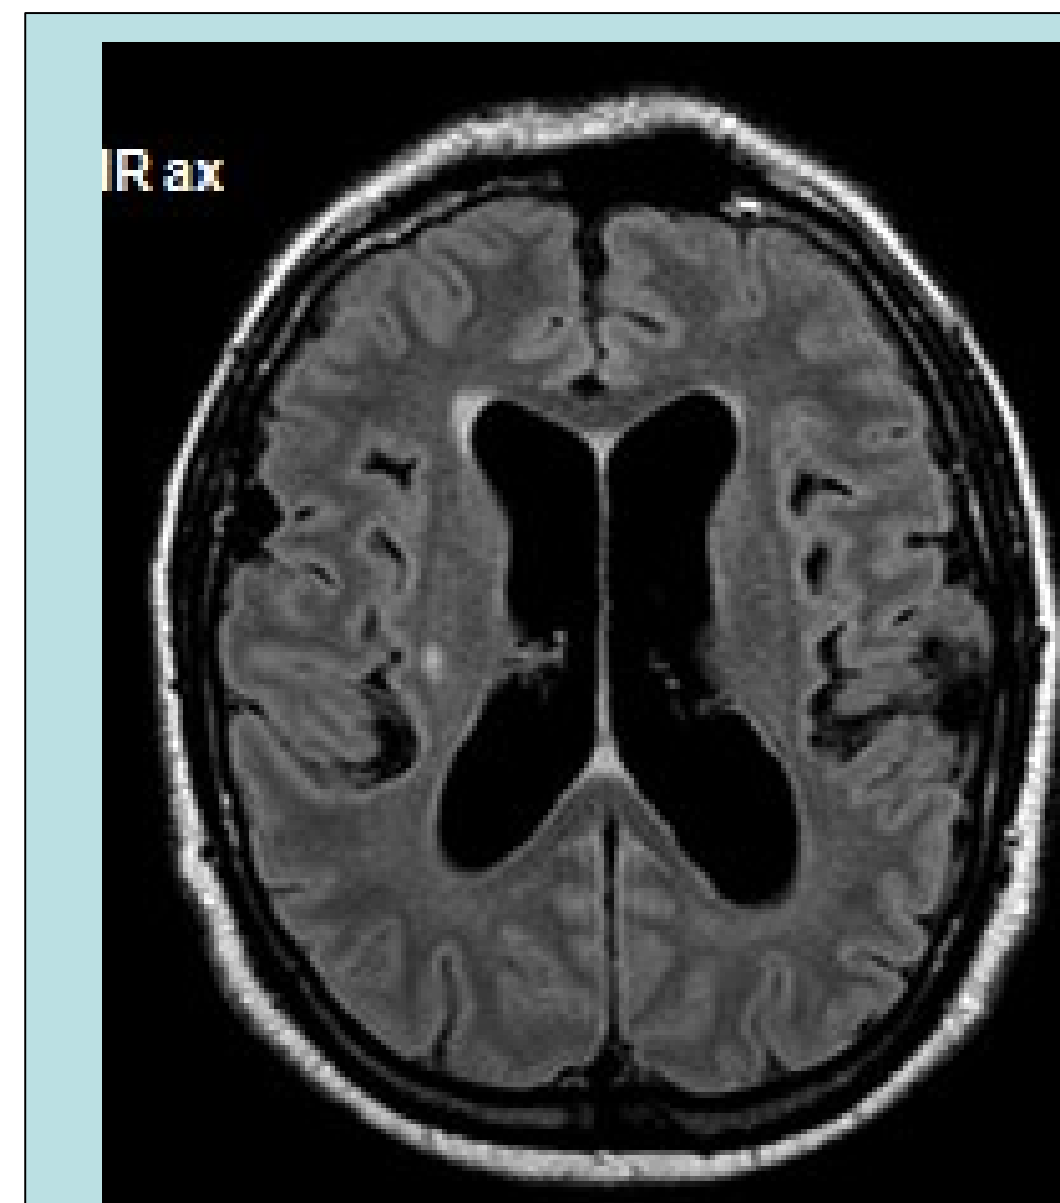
FLAIR axial shows marked ventricular dilatation, disproportioned to sulcal enlargement
